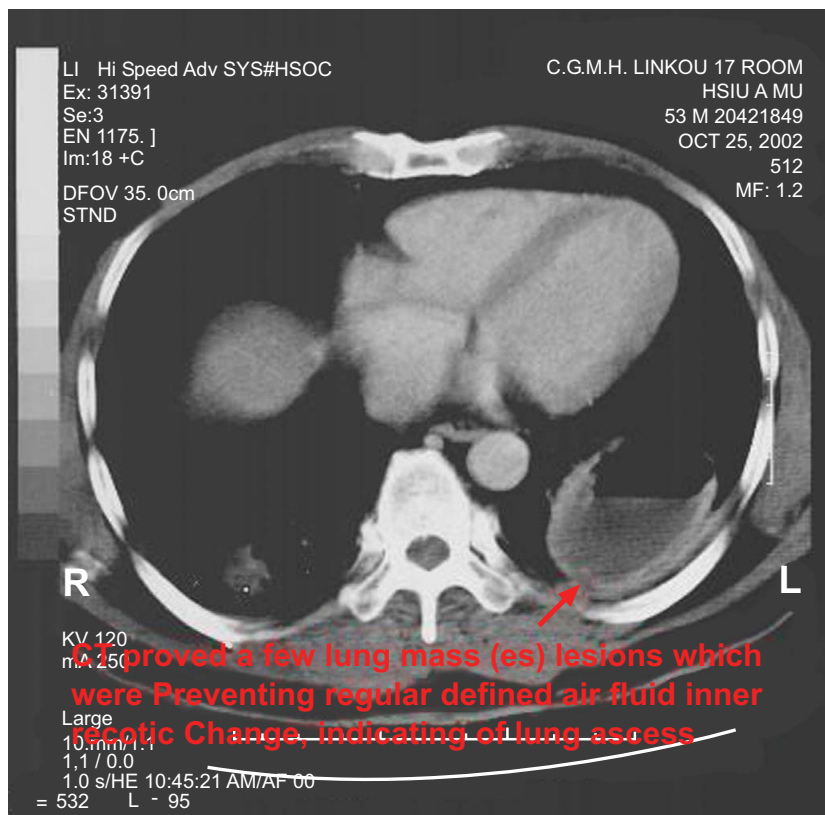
CT scan: air-fluid level, R/O lung abscess.
